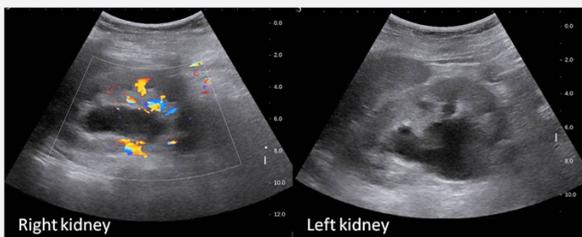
An 84-year-old female patient presents with renal function deterioration. Sonography shows bilateral hydronephrosis.
